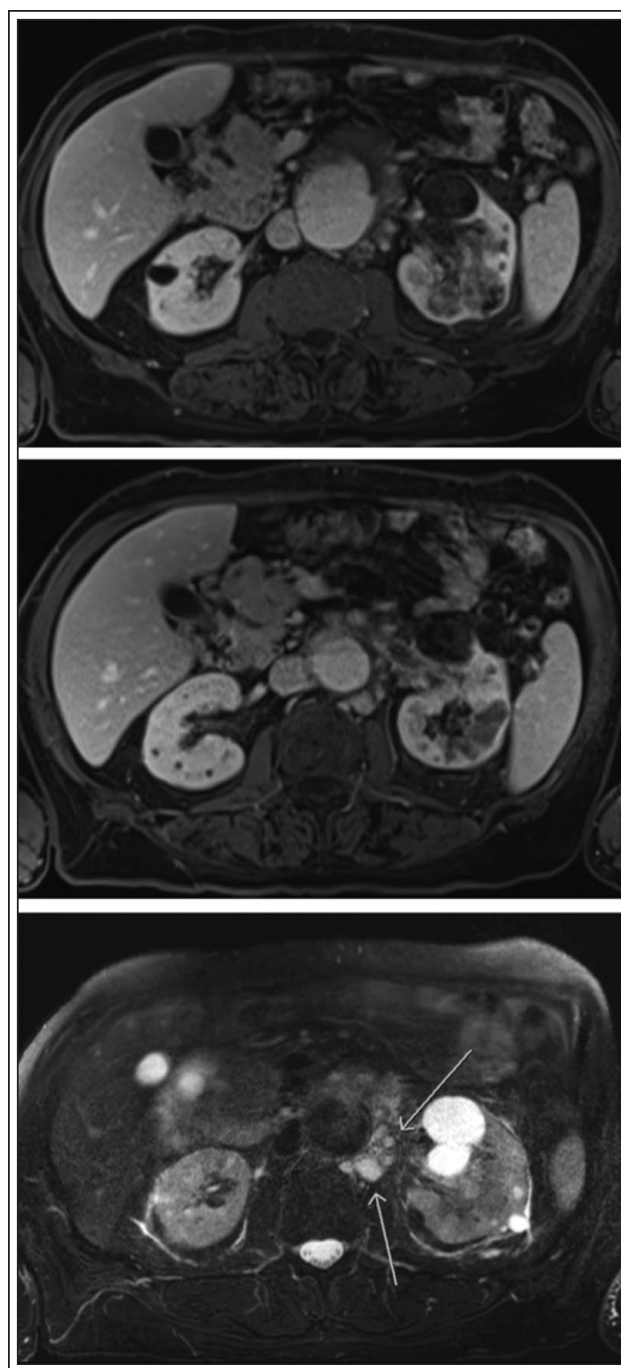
MRI with and without contrast demonstrating infiltrative left renal mass with vein thrombus and peri-aortic lymphadenopathy.
